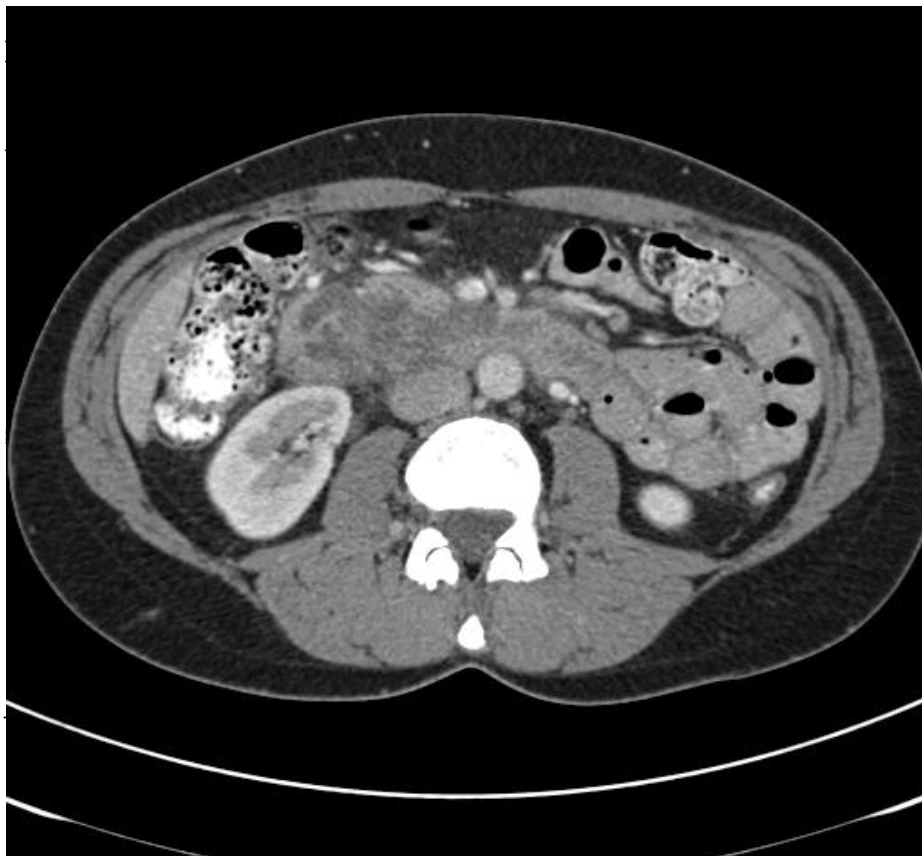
Post EUS-FNA CT showing inflammation of distal duodenum.
